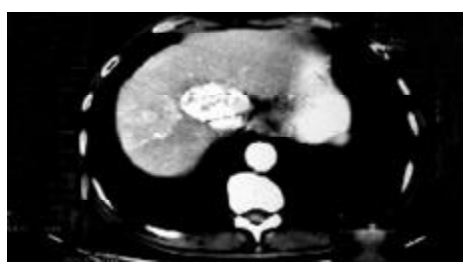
Pre-operative CT scan shows the tumor originating in caudate lobe, post-operative CT scan shows splitting line (arrow).
